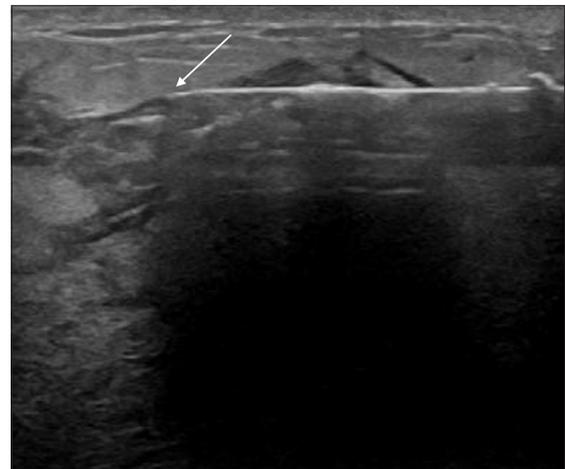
A 57-year-old woman who presented with a new breast lump. The right breast ultrasound guided biopsy at 10 o'clock with tissue sampling of the hyperechoic breast parenchyma. Posterior shadowing seen in this image is an artifact due to the biopsy needle (as indicated by arrow).
